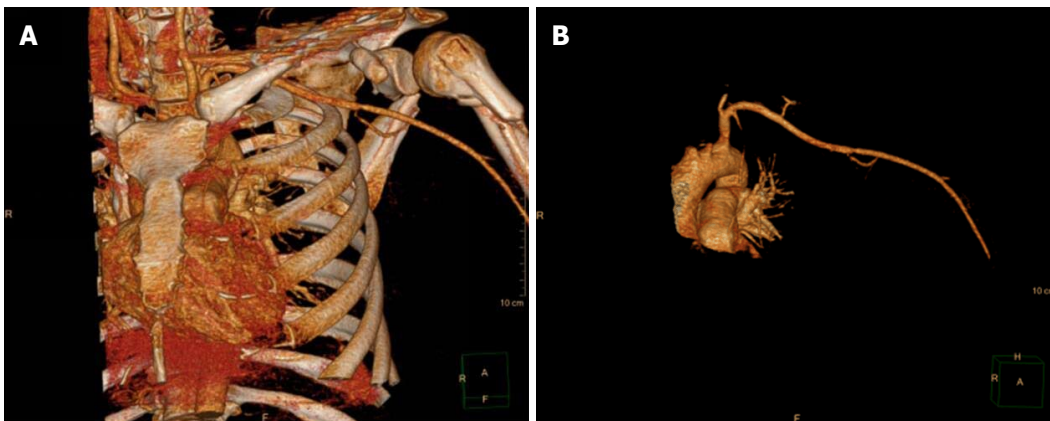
Evidence that axillary artery injury was successfully repaired. A: Computed tomography (CT) angiography confirmed that blood flow of the left axillary artery was restored after vascular repair; B: CT angiography without bone confirmed that blood flow of the left axillary artery was restored after vascular repair.
